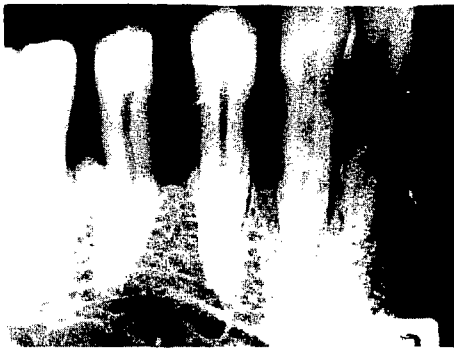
Radiograph of the lesion after removal of the buccal wall.
